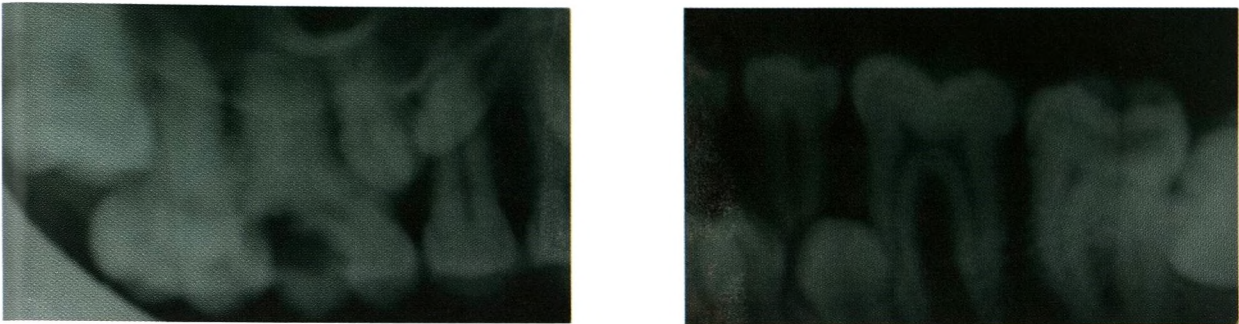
(a, b) The Intra-Oral-Periapical (IOPA) radiographs in relation to both carious teeth
